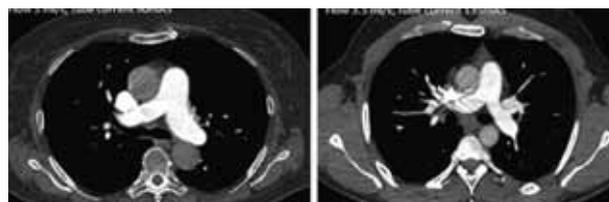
There are many parameters such as kV, mAs and contrast media. The above example is CT angiography using a HCCM and low mAs protocol. Left Panel: High flow (5mL/s) of lomeron 400 mg/mL; low mAs. Right Panel: Moderate flow rate (3.5mL/s) lomeron 400 mg/mL and high mAs). Constant kV. The high flow/low mAs protocol enabled a reduction in radiation dose by 33% with a higher image quality and contrast-to-noise ratio
